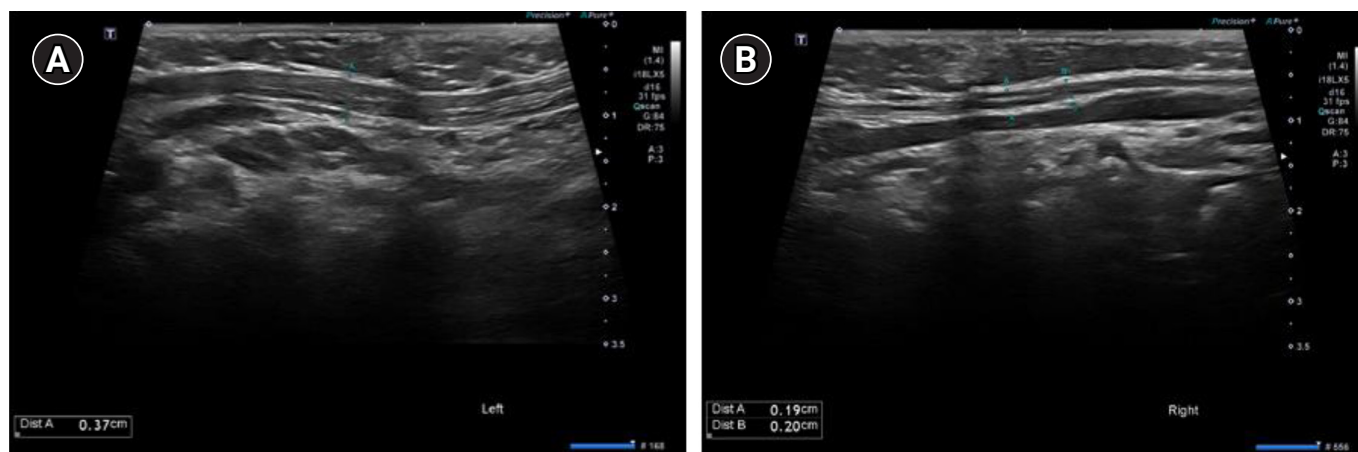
Ultrasonography findings of the sternocleidomastoid muscle (SCM). (A) The left SCM thickness was measured as 0.37 cm. (B) The right SCM thickness was measured as 0.19 cm. There was asymmetric thinning of the right SCM without any fibromatosis colli.
